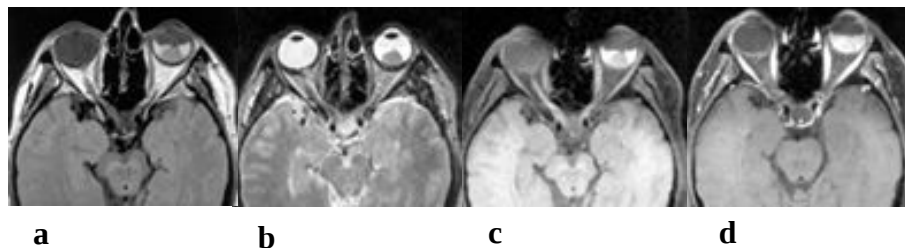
a, b. MR, T1-weighted (a) and T2-weighted (b) images of the orbits. An isointense mass is seen in the left globe, growing toward the vitreous body. The mass is surrounded by a hyperintense retinal detachment. (c, d). Fat suppressed images, without (c) and with (d) contrast injection. The melanoma enhances following injection of contrast and becomes hyperintense (d).
